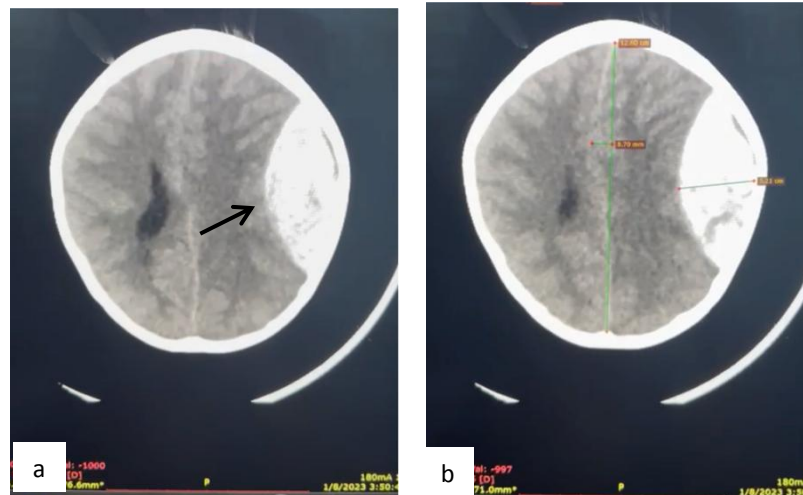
a. Initial CT scan showed large temporoparietal EDH. b. Size of EDH showed 3 cm with midline shift 0.8cm.
